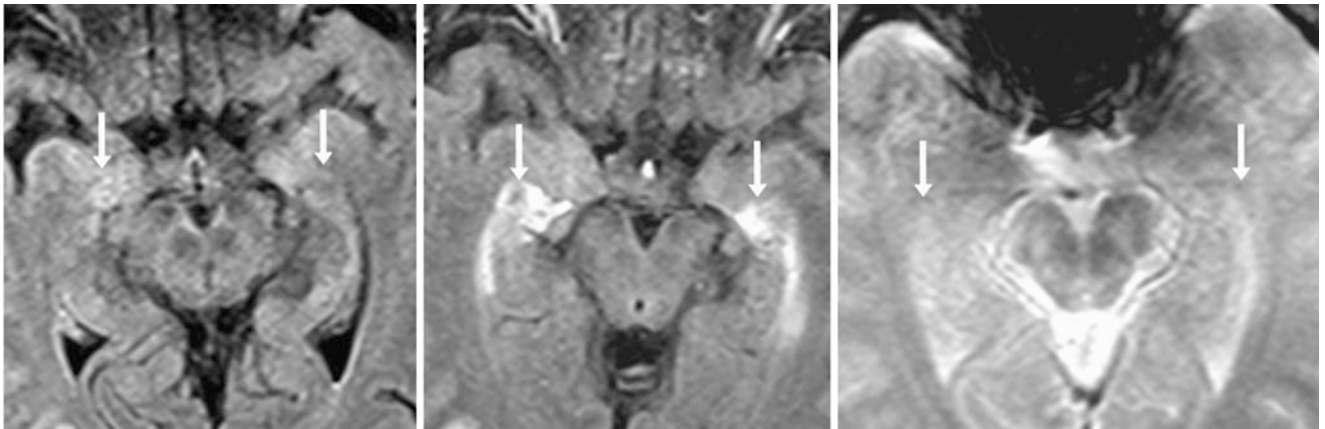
A 61-year-old patient with CP visualized (*arrows*) on non-contrast FLAIR images (*left*) and with quite avid enhancement on post-contrast FLAIR images (*middle*), which occurs because the CP lacks a
